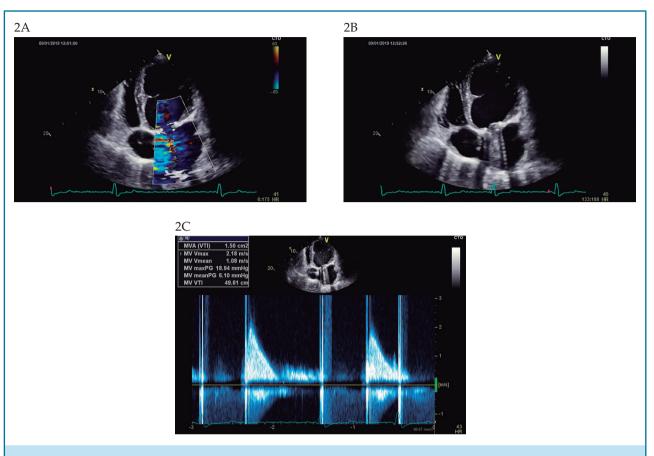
Transthoracic echocardiography in an apical four-chamber view showing dilatation of right cardiac chamber, mitral mechanical prosthesis with preserved disc motion and moderate depression of left ventricular systolic function (figure 2A). Color Doppler with no evidence of abnormal regurgitation (figure 2B) and continuous Doppler showing transprosthetic gradients and functional area compatible with a normally functioning prosthetic valve (figure 2C). To view the video click on the link: http://publicacoes.cardiol.br/portal/ijcs/ingles/videos/2019-0138/2019-0138.asp
